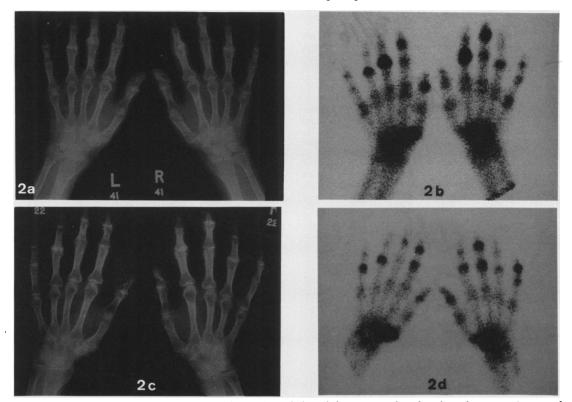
(a) Initial and (c) follow up hand radiographs and (b and d) corresponding four hour bone scan images of a patient with generalised nodal arthritis. The following points can be noted: (1) Joints that are abnormal both on scan and x ray with varying degree of abnormality on each modality. (2) Progression of all initially scan positive joints. (3) Lack of change of radiographic features of x ray abnormal but scan normal DIP left little finger. (4) Ankylosis of left middle PIP in association with loss of scan abnormality. (5) Progression of the DIP left little finger of the right hand that is initially scan normal but becomes scan abnormalit. (6) Development of marked scan abnormality of the right middle PIP with only minimal radiographic abnormality.
